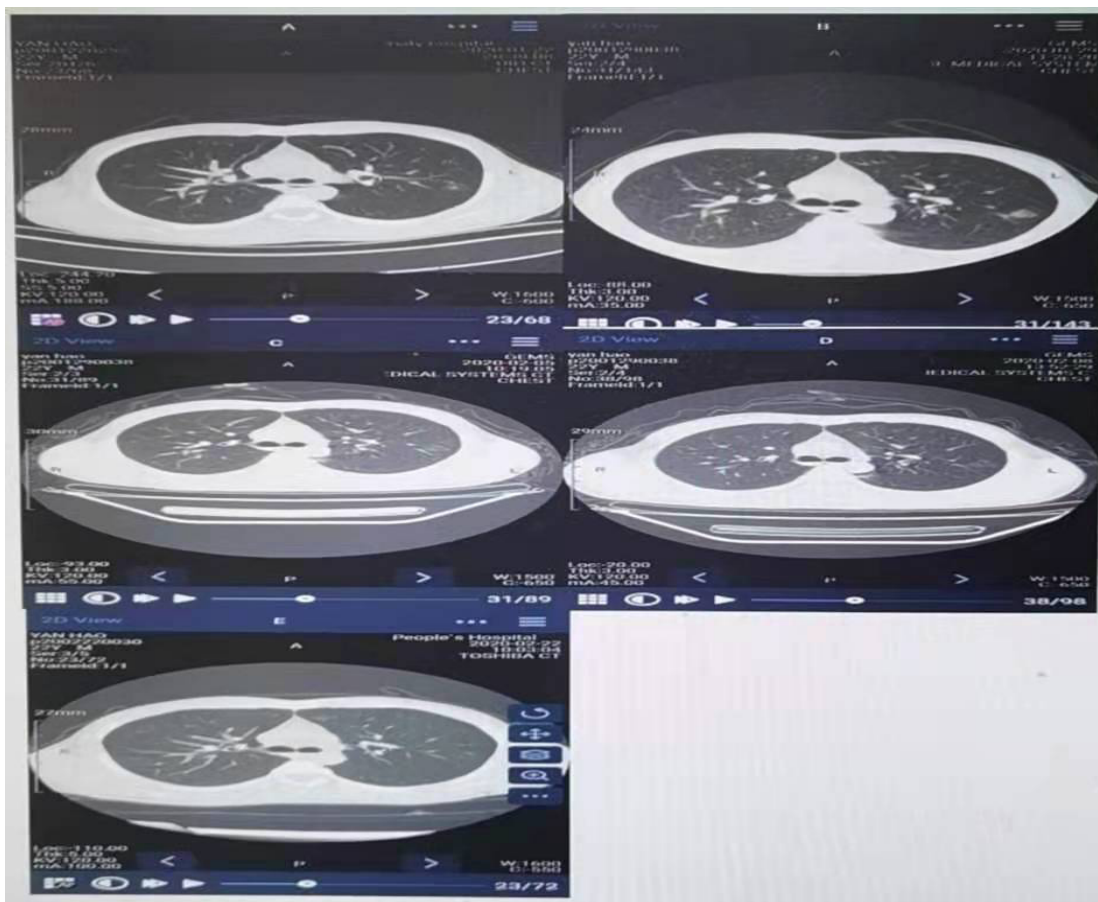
Chest CT: A, B, C, D, E are chest CT images on January 22, January 29, February 5, February 8, and February 22, respectively
